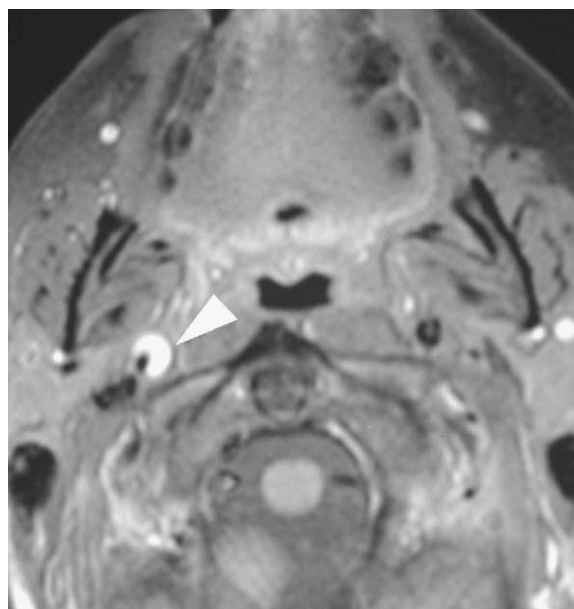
T1-weighted, fat-saturated, transverse MR image in a patient with ICA dissection, demonstrates an eccentric hyperintense rim of intramural haematoma (arrowhead) and narrowing of the vessel lumen.
